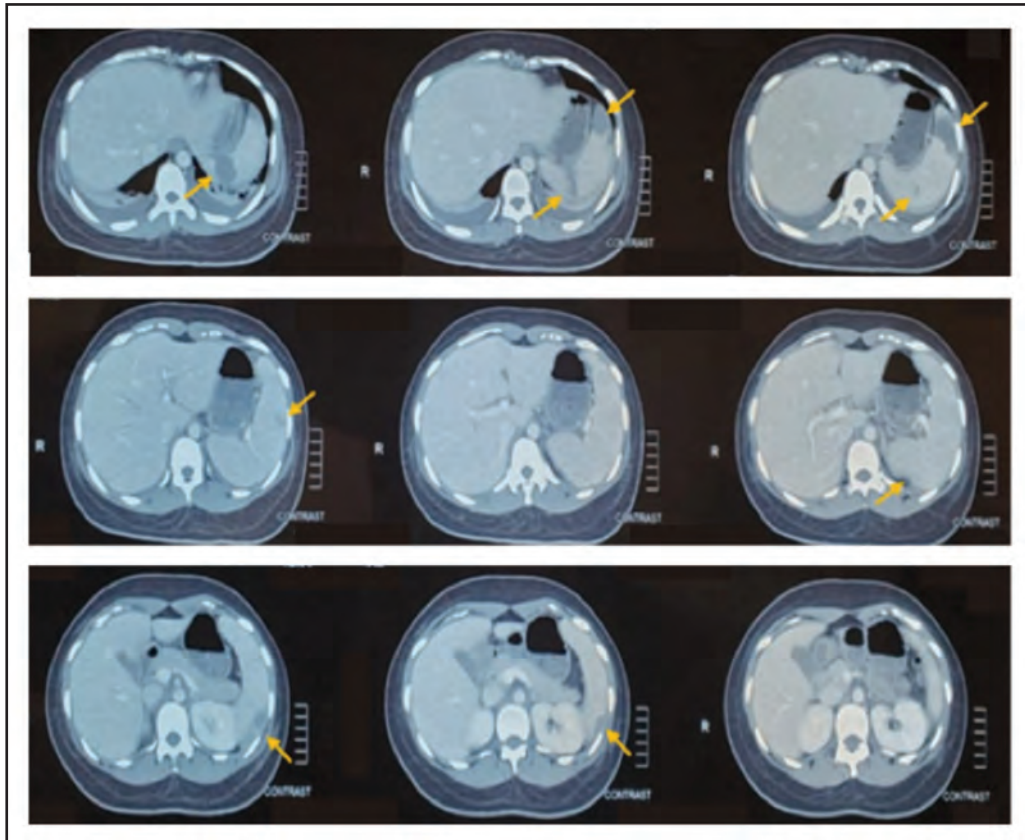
CT Abdomen and pelvis showing multiple wedge-shaped non-enhancing hypodense lesions in the spleen with the largest lesion in the upper pole measuring 2.2 cm × 4.0 cm × 2.9 cm, representing splenic infarct (yellow arrows pointing to the infarcts within the spleen).
